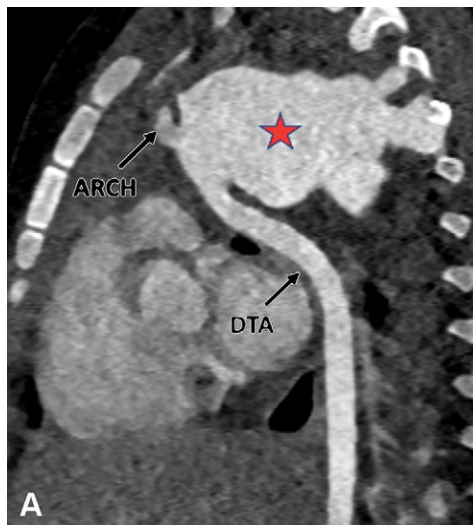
Postoperative appearance of type A interrupted aortic arch after primary anastomosis repair in a 17-year-old boy. (A) Sagittal oblique maximum intensity projection (MIP) CT image shows a large pseudoaneurysm (red star) arising at the site of anastomosis (junction of aortic arch and descending thoracic aorta). (B) Axial MIP CT image shows the large lobulated pseudoaneurysm (red star) occupying the thoracic cavity, displacing the adjacent lung parenchyma peripherally and extending into the neural foramen (yellow arrow). A nonenhancing hypodense thrombus (green arrow) is observed within it. (C) Volume-rendered image confirms the findings. Note the broad neck of the pseudoaneurysm (red star) arising from the site of anastomosis. Ao = aorta, BA = brachiocephalic artery, DTA = descending thoracic aorta, LCC = left common carotid artery, LSA = left subclavian artery, RCC = right common carotid artery.
